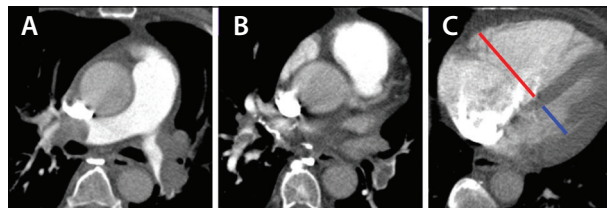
CT slices prior to thrombectomy. Extensive clot burden in the right and left PA (A). Clot extended into the subsegmental branches (B). RV (red)/LV (blue) ratio was 2.2, indicating extensive right heart strain (C).
